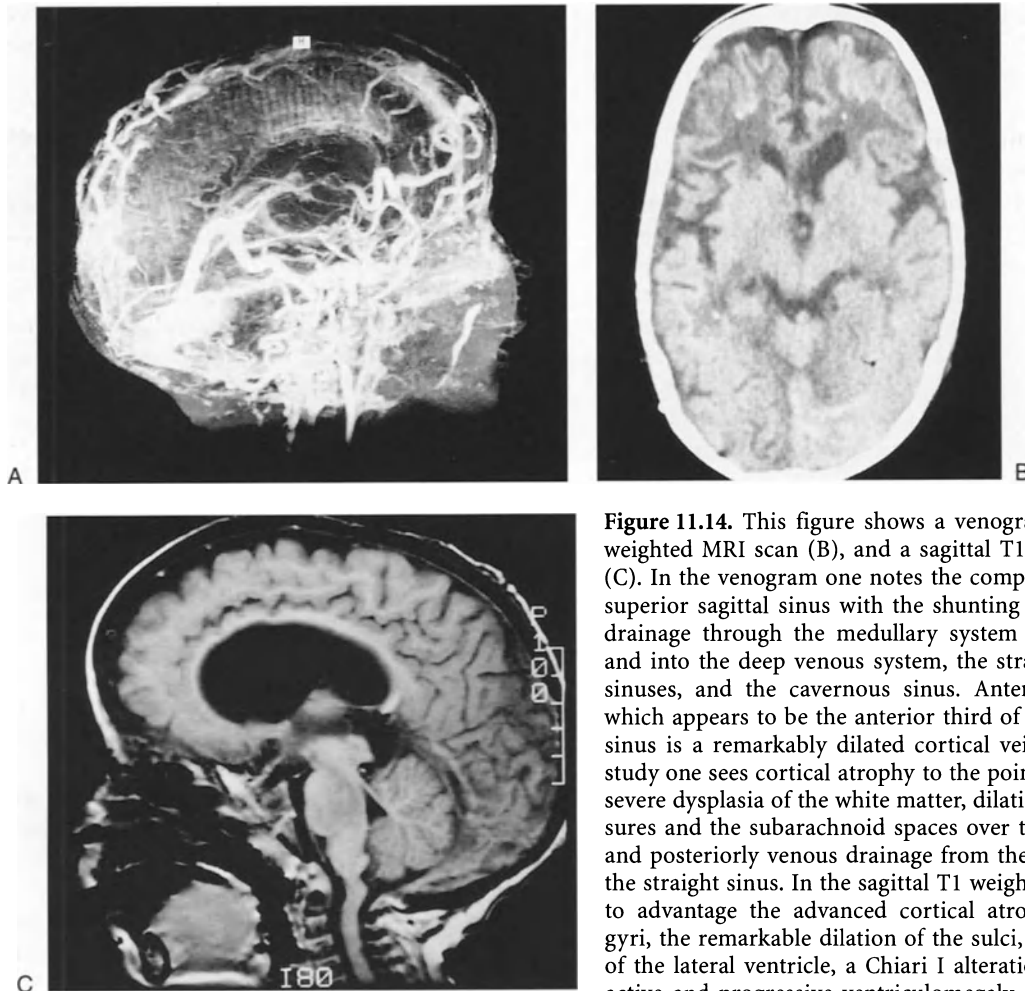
This figure shows a venogram (A), an axial T1 weighted MRI scan (B), and a sagittal T1 weighted MRI scan (C). In the venogram one notes the complete occlusion of the superior sagittal sinus with the shunting of all of the venous drainage through the medullary system of the hemispheres and into the deep venous system, the straight and transverse sinuses, and the cavernous sinus. Anteriorly, the structure which appears to be the anterior third of the superior sagittal sinus is a remarkably dilated cortical vein. In the axial MRI study one sees cortical atrophy to the point of redundant gyri, severe dysplasia of the white matter, dilation of the sylvian fissures and the subarachnoid spaces over the insula bilaterally, and posteriorly venous drainage from the occipital lobes into the straight sinus. In the sagittal T1 weighted image one notes to advantage the advanced cortical atrophy and redundant gyri, the remarkable dilation of the sulci, progressive dilation of the lateral ventricle, a Chiari I alteration secondary to the active and progressive ventriculomegaly, and buckling at the bulbomedullary junction as a complication of tonsillar herniation: tetraventricular hydrocephalus of the communicating variety superimposed upon progressive cerebral atrophy secondary to complete occlusion of the superior sagittal sinus.
